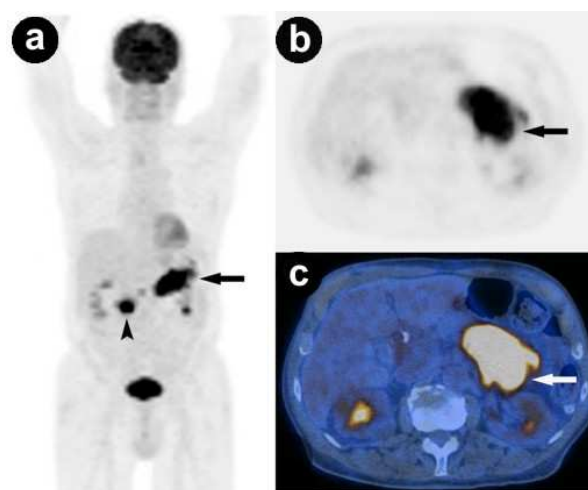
a. Original attenuation-corrected coronal PET image demonstrates high uptake in the pancreatic head (arrowhead) and tail (arrow). b. c. Original attenuation-corrected axial PET image at the level of the pancreas shows high uptake in the pancreatic tail (arrow). Corresponding fused FDG-PET/CT at the same level.
